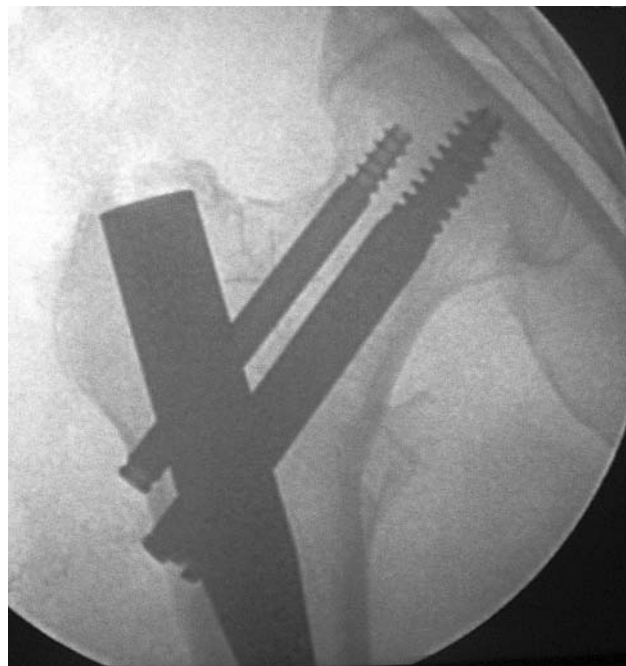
Intra-operative radiograph of right hip showing treatment with long PFN following A3 fracture. Tip-Apex distance is 27.9 mm.
